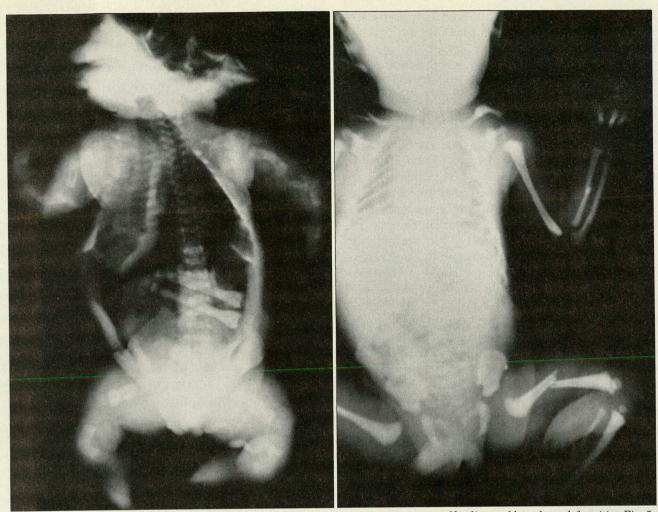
(Case 1). Postmortem x-ray view demonstrates multiple fractures at various stages of healing and long-bone deformities. Fig. 5. (Case 2). X-ray of viable infant with multiple intrauterine fractures.
